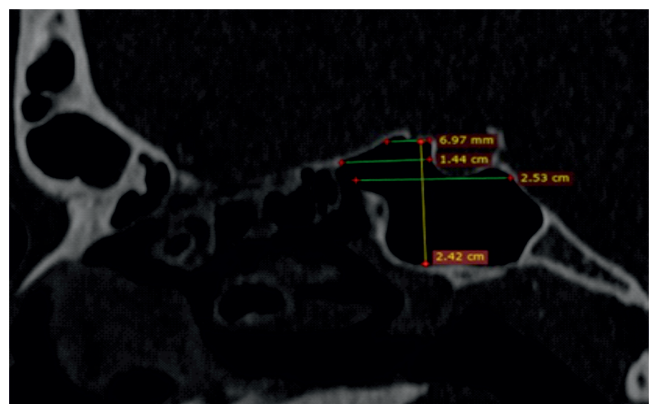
Sagittal CT image (Bone window) through sphenoid sinus showing measurement of suprasellar, presellar & infrasellar depth (horizontal lines from above downwards) and presellar height
